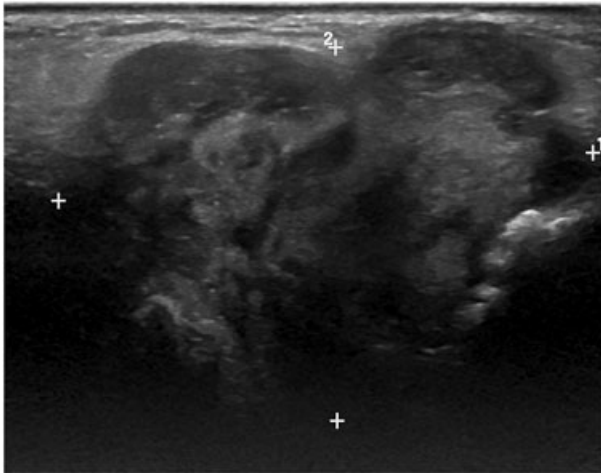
B-mode ultrasound demonstrates a solid, lobulated, heterogeneous mass arising from the subtalar joint.
